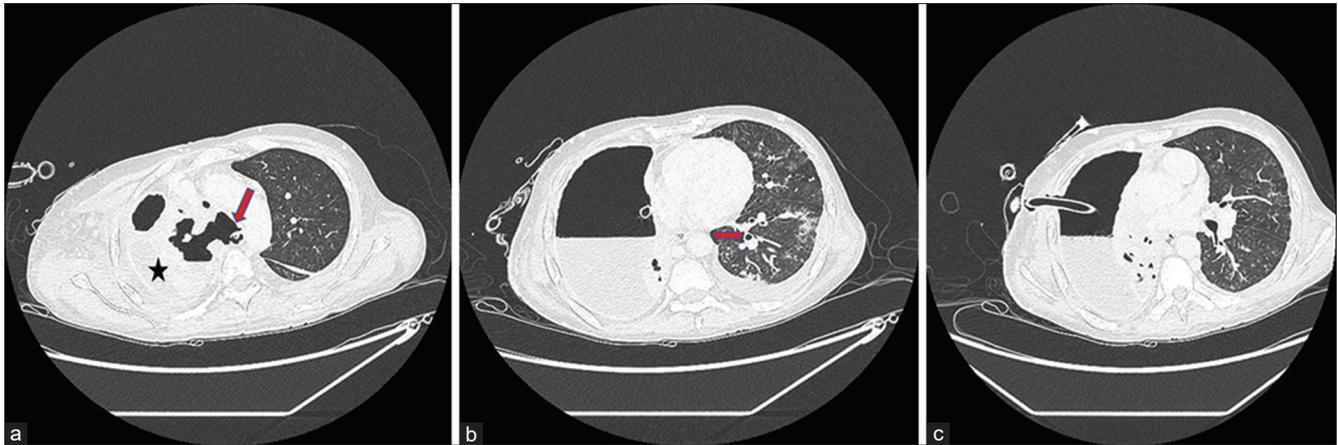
(a) CT chest showing right-sided hydropneumothorax with ICD and RUL mass. (b) Intact trachea with oesophagus is also seen (white arrow)
